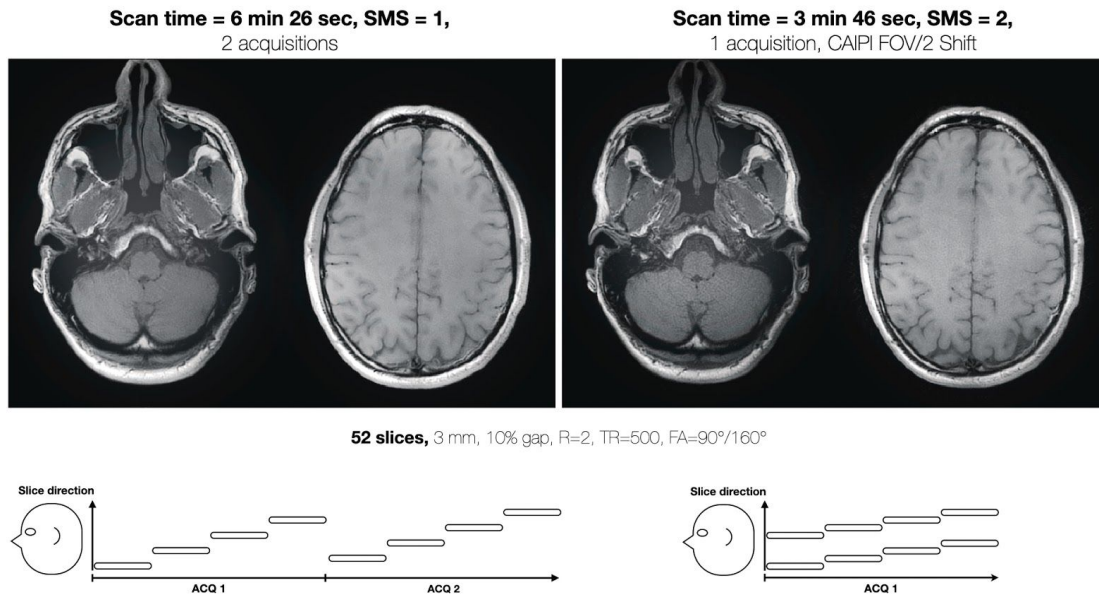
Left: Two slices of a T1-weighted PROPELLER scan divided into two acquisitions to keep the TR around 500 ms. Right: Two simultaneously excited slices of a SMS accelerated T1-weighted PROPELLER scan that now could be acquired in one acquisition.
